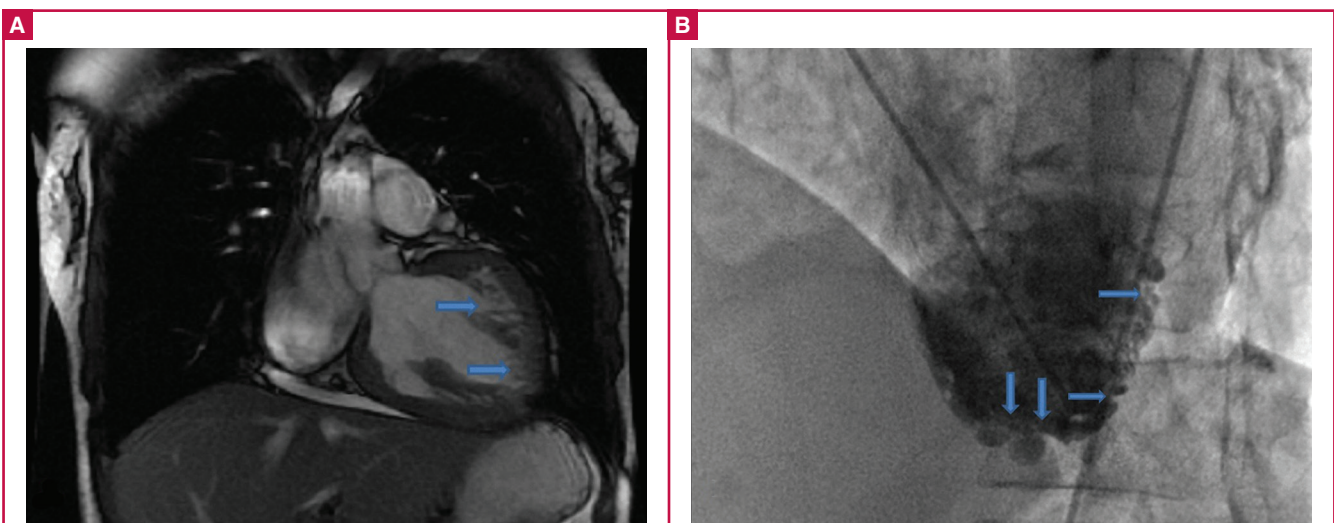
(A) Multiple deep trabeculae and inter-trabecular recesses of the left ventricle can also be demonstrated by MRI. (B) Left ventriculogram of the patient showing inter-trabecular recesses, especially in the left ventricular apical and lateral wall.
